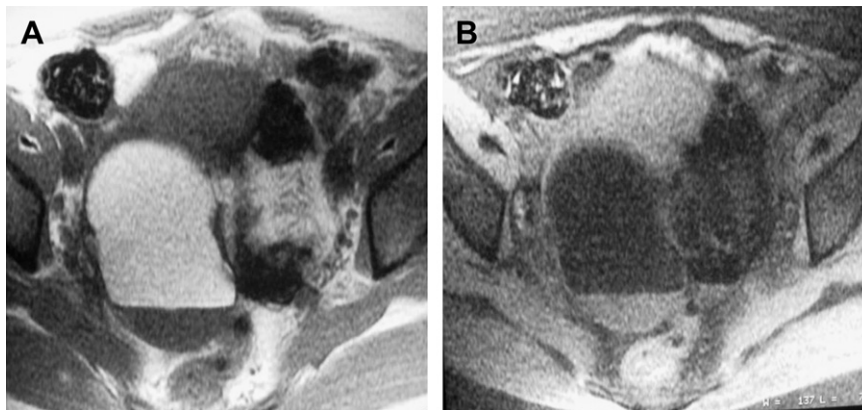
Right adnexal teratoma. Lesion shows high SI on T1-weighted image, and low SI on T1-weighted image with fat suppression. (A) T1-weighted image. (B) T1-weighted image with fat suppression.
